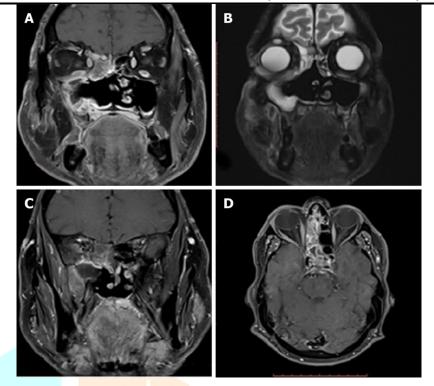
Magnetic resonance imaging of the patient of figure 1 showing.
